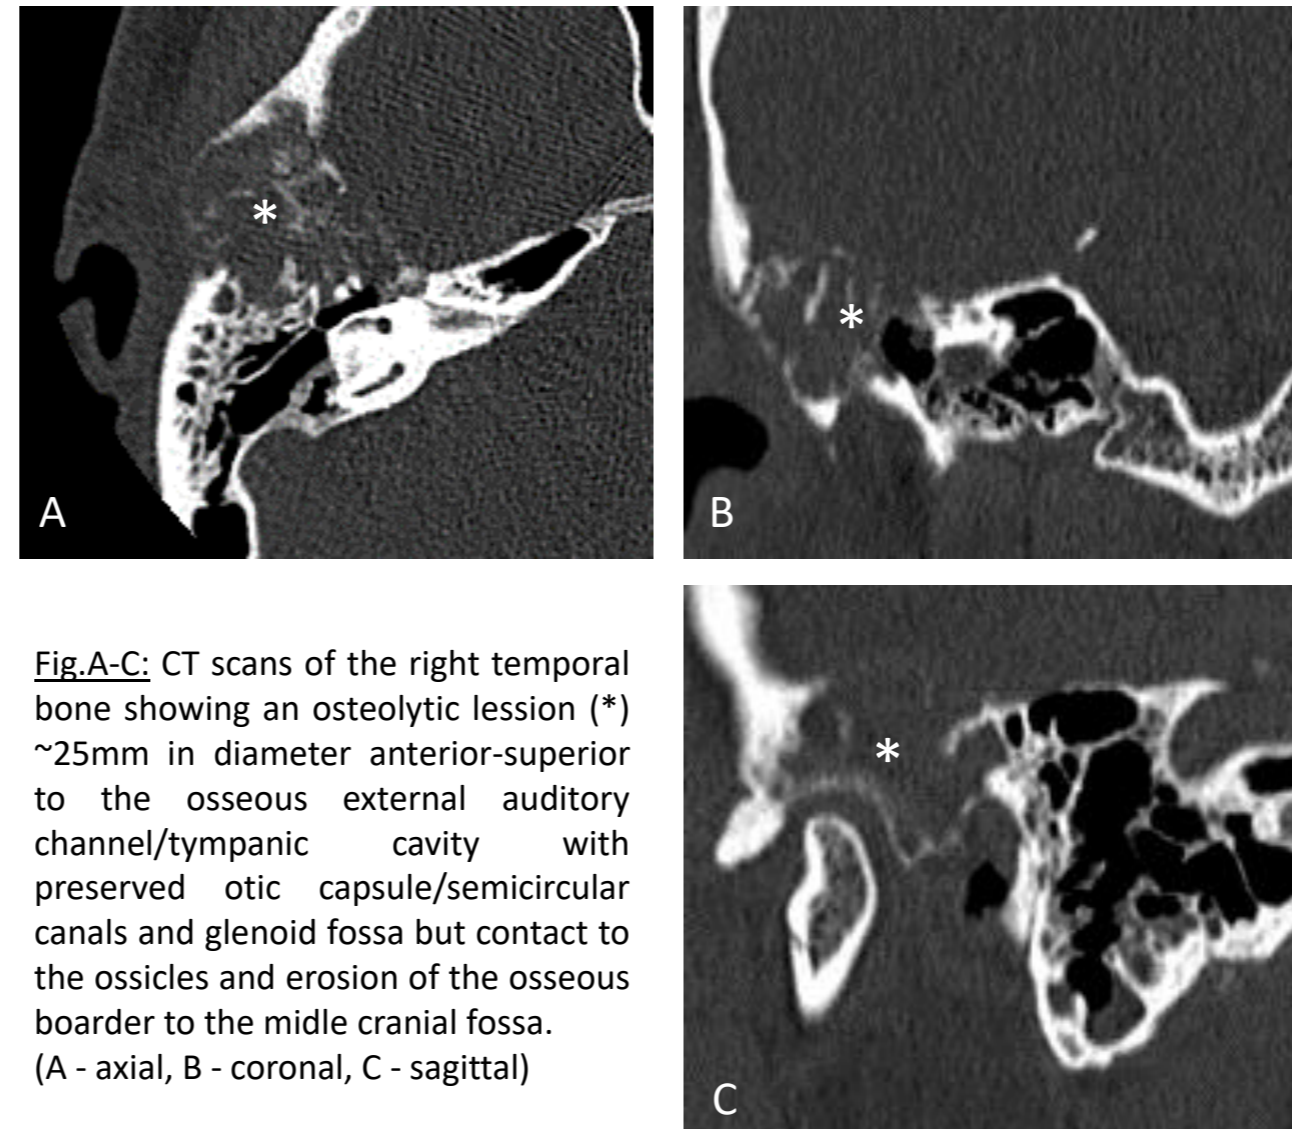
A-C: CT scans of the right temporal bone showing an osteolytic lesion (*) ~25mm in diameter anterior-superior to the osseous external auditory channel/tympanic cavity with preserved otic capsule/semicircular canals and glenoid fossa but contact to the ossicles and erosion of the osseous boarder to the middle cranial fossa. (A - axial, B - coronal, C - sagittal)
